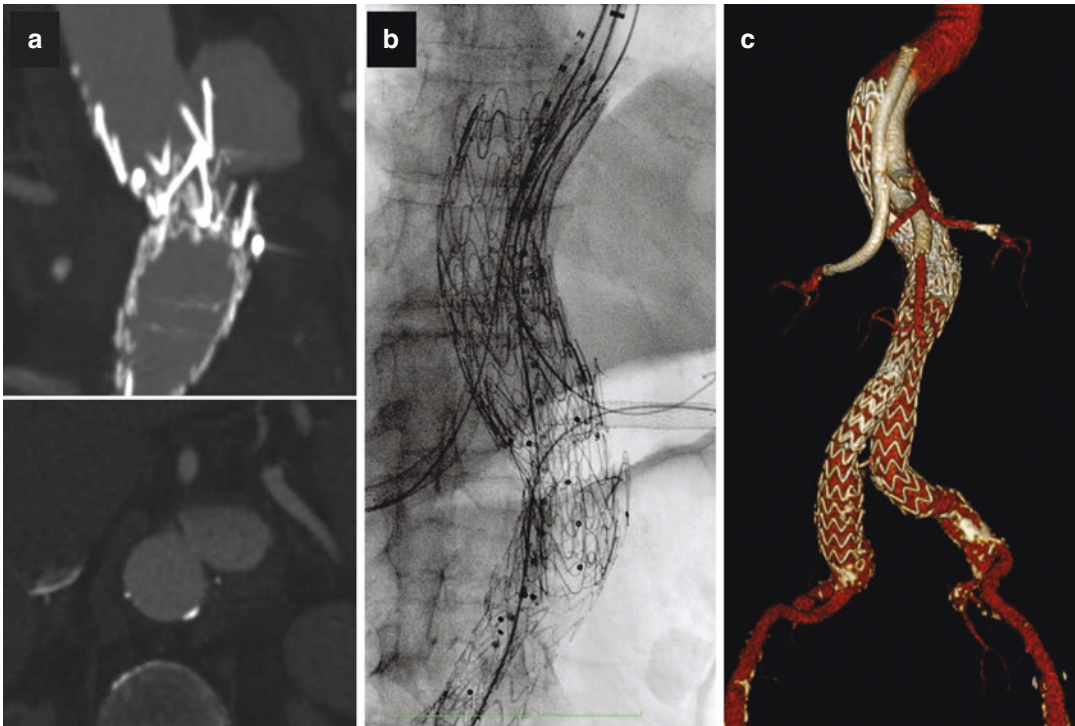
(a) Preoperative sagittal and axial CT images showing the mycotic at renal arteries level, just above the implanted endograft; (b) intraoperative finding with all devices in place (3 chimney, 1 periscope); (c) postoperative
